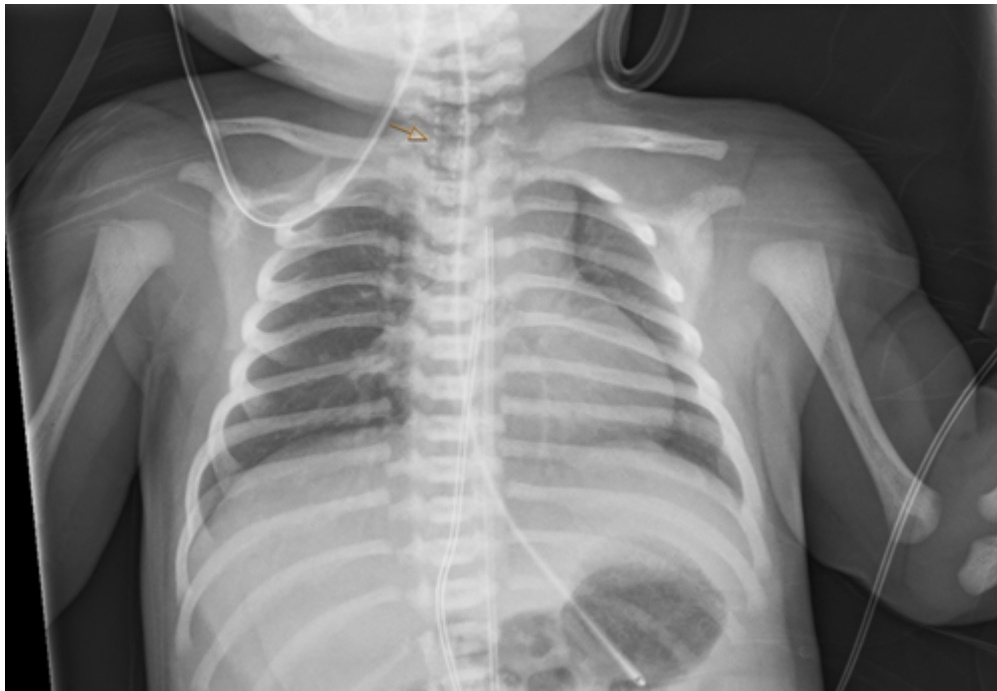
Frontal chest radiograph showing linear and nodular calcifications along the tracheal wall.
